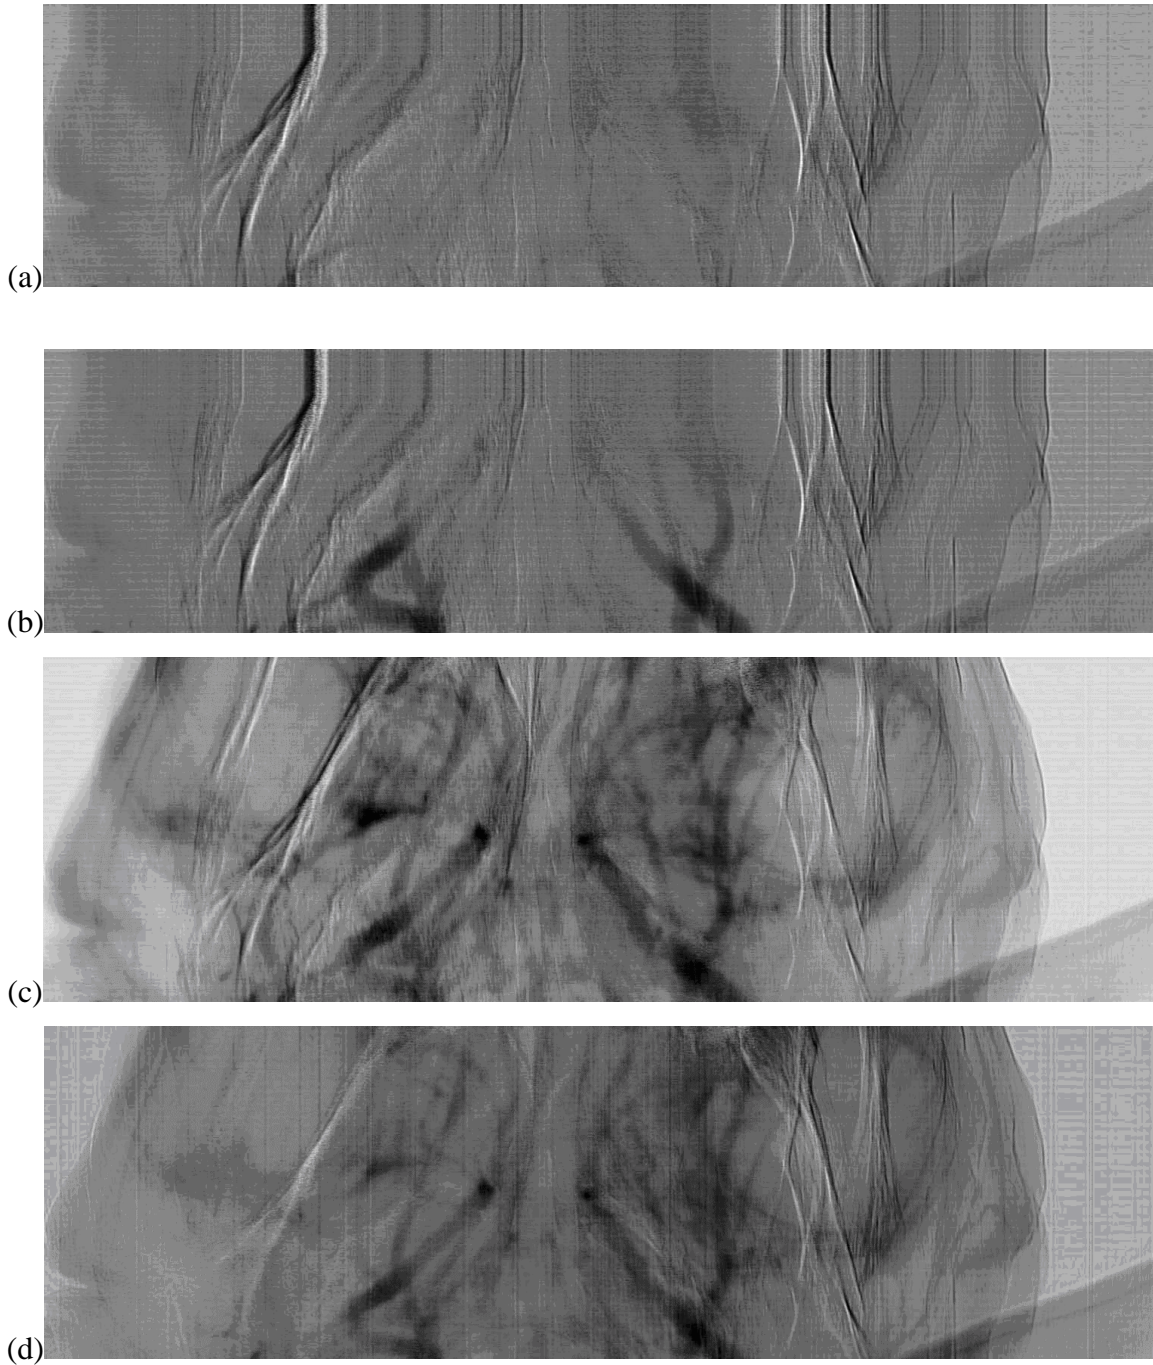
Images of the cerebral arteries acquired with the FRELON camera in radiography mode; pixel size $47 \times 47 \mu\text{m}$,; Iomeprol[®] 1 mL/sec for 3 seconds. Image 1 was acquired with 10 seconds delay after injection (a). Early (b) and late (c) arterial filling phases. End of arterial phase (d). (reprinted with permission)
